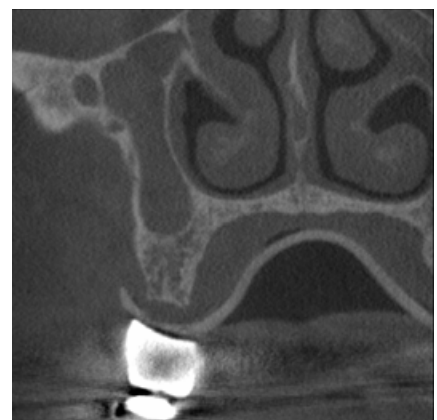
Coronal CBCT image, second premolar region
